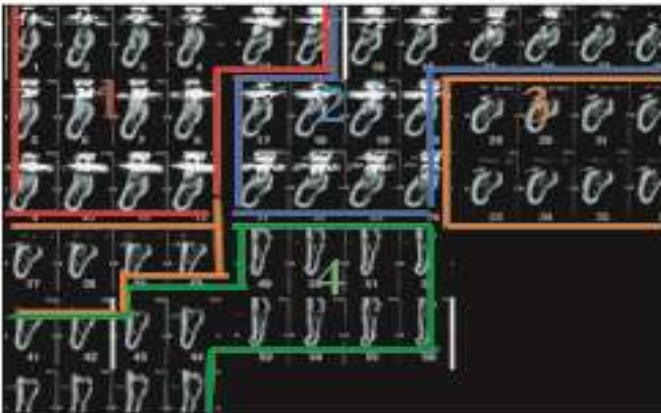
Cross-sectional CT images between the mental foramen and the mandibular foramen with intervals of 1 mm. The MC is divided into equal 4 areas: area A (No. 1-14), area B (No. 15-28), area C (No. 29-42) and area D (No. 43-56), from anterior to posterior. Each area has an equal number of cross-sectional images.
